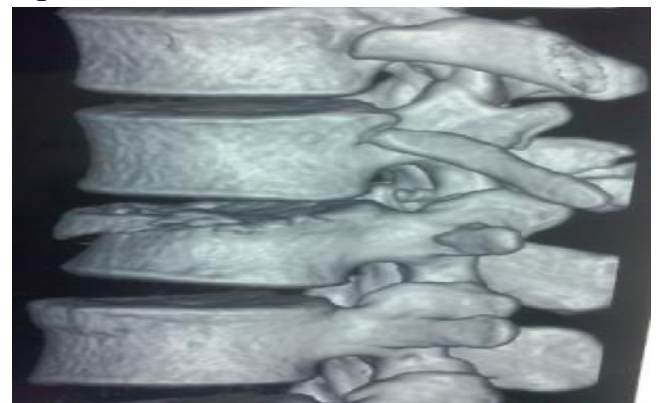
3D CT image of L1 vertebral body
